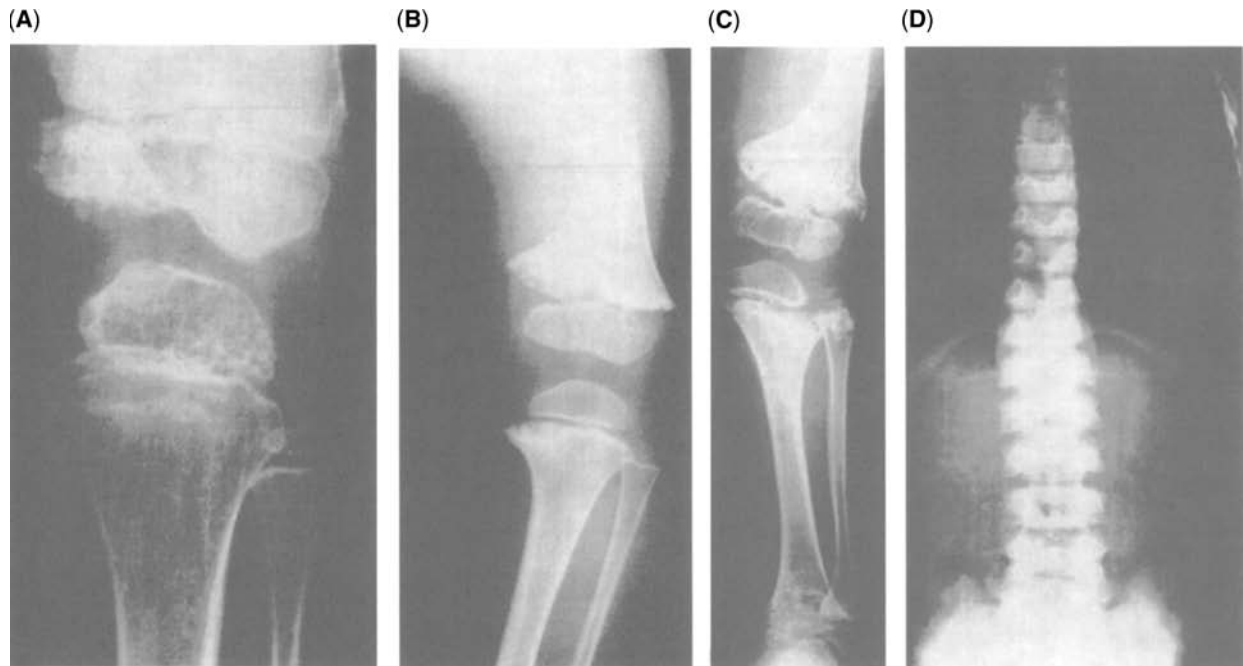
Radiographs of knee (A–C) and spine (D) from patients with a variety of chondrodysplasias. (A) Epiphyseal dysplasia: note the small irregular epiphyses and normal metaphyses from a patient with spondyloepiphyseal dysplasia congenita. (B) Metaphyseal dysplasia: note the irregular and widened metaphyses with normal epiphyses from a patient with metaphyseal dysplasia, Schmid type. (C) epimetaphyseal dysplasia: note the abnormal epiphyses and metaphyses from a patient with spondyloepimetaphyseal dysplasia, Strudwick type. (D) Platyospondyly: note the flat and irregular vertebrae from a patient with spondylometaphyseal dysplasia, Kozlowski type.
